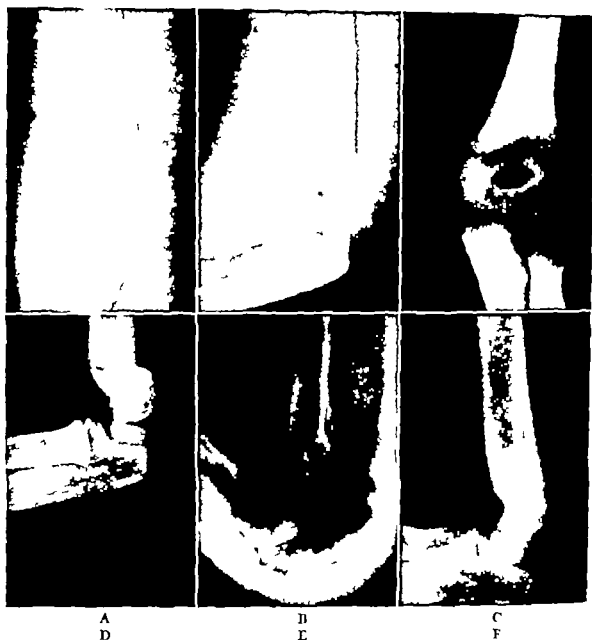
Roentgenograms of supracondylar fracture of humerus. (A) and (B) Anteroposterior and lateral views barely showing fracture line and minimal displacement requiring no reduction. (C) and (D) Show similar views in another child with moderate displacement. (E) Lateral view after partial reduction and (F) later view of same elbow two and one half years later
